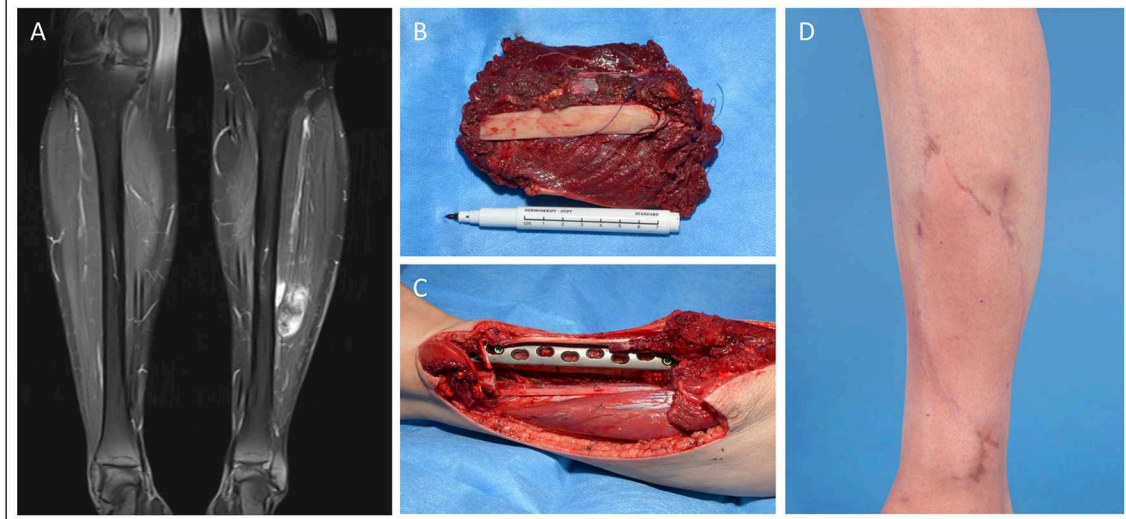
Patient operated in an interdisciplinary approach for synovial sarcoma of the lower extremity. (A) Pre-OP MRI of the lower extremity with visible mass in the left lower leg. (B) Excised tumor tissue with resected fibula segment. (C) Tumor bed with prophylactic plate osteosynthesis on tibia. (D) Clinical presentation in the 6 months follow-up.
